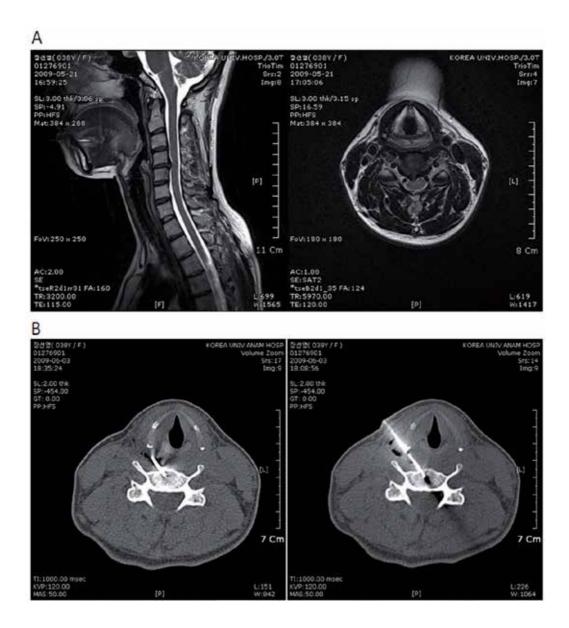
(A) Pre-procedure MRI noted a central disc extrusion at C4/5.(B) Placing the tip of the L-DISQ catheter into the herniated disc with computed tomography guidance of the standard midline approach
